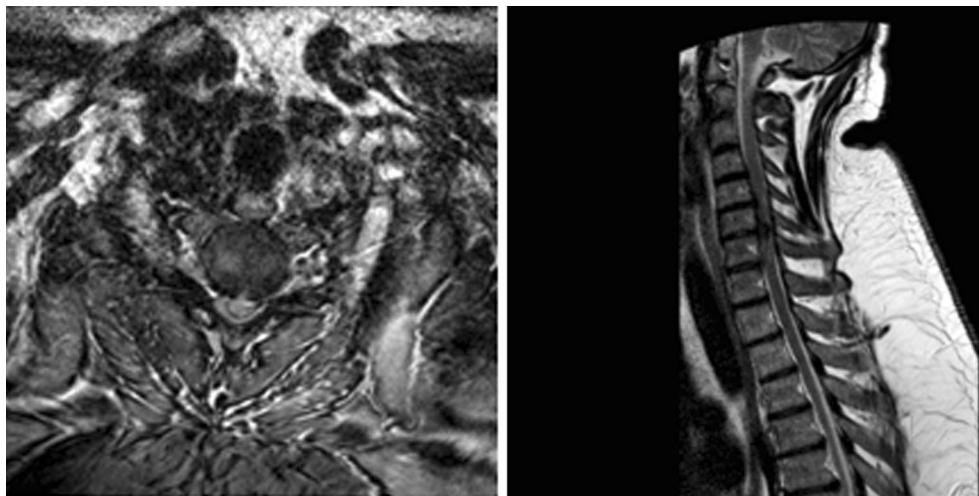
Sagittal and axial MRI showing massive C6/7 disc prolapse
